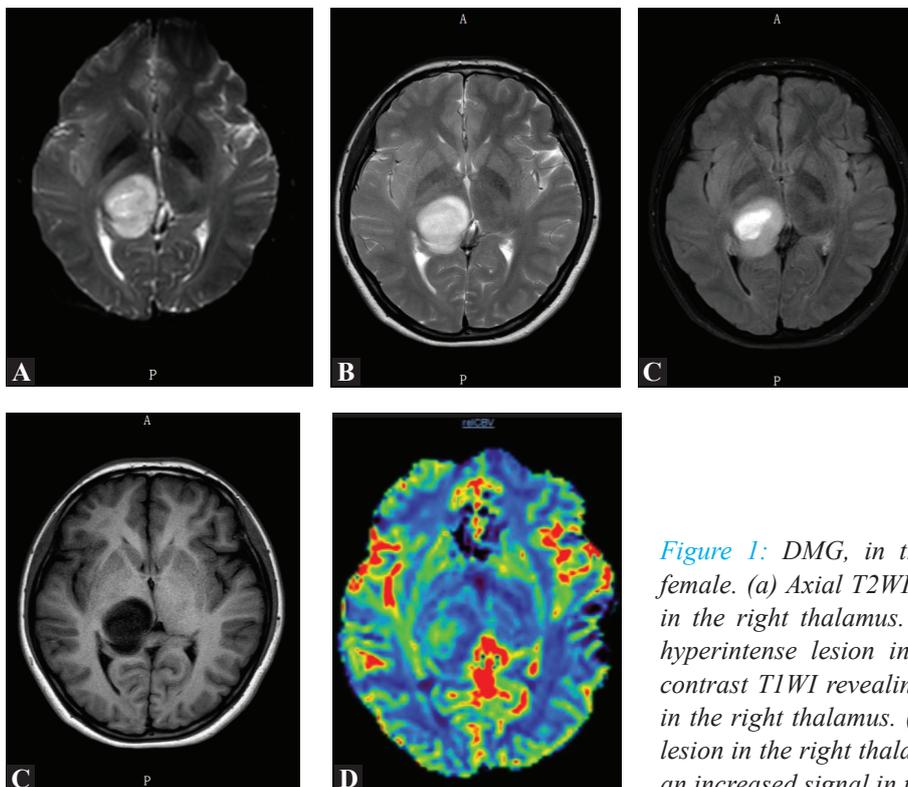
DMG, in the right thalamus in a 19-year-old female. (a) Axial T2WI demonstrating a hyperintense lesion in the right thalamus. (b) Axial FLAIR image revealing a hyperintense lesion in the right thalamus. (c) Axial pre-contrast T1WI revealing homogeneously hypointense lesion in the right thalamus. (d) Axial DWI reveals a hyperintense lesion in the right thalamus. (e) CBV parameter map reveals an increased signal in the right thalamus.
